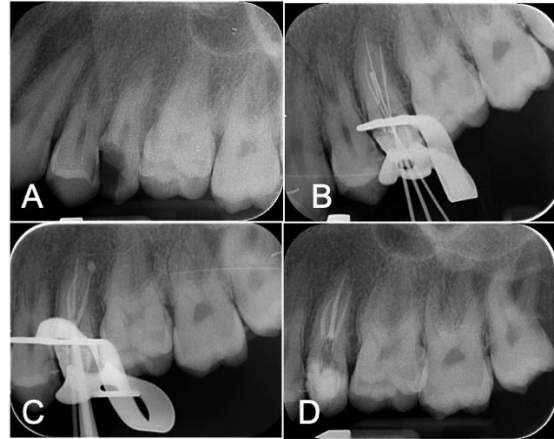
#25: (A) Preoperative periapical radiograph; (B) periapical radiograph with GP removed and working length determined; (C) periapical radiograph with master cones; (D) periapical radiograph showing final obturation.
